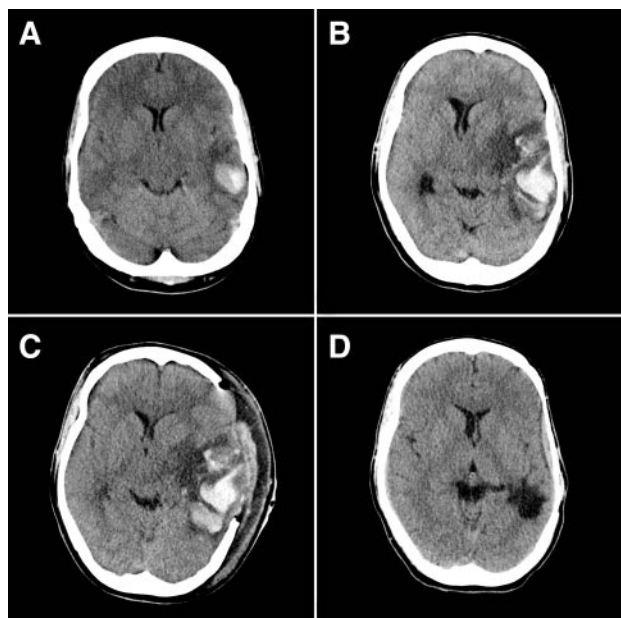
A, Admission head CT-scan shows left temporal hemorrhagic infarct (34 cm³). B, CT scan acquired after clinical deterioration, showing enlargement of hemorrhagic infarct (110 cm³) and increase of midline shift (12 mm). C, Direct postoperative CT scan. Reduction in midline shift (7 mm). D, Follow-up CT scan 3 months after ictus.
